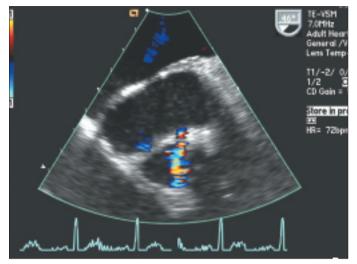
Transesophageal color Doppler images showing bidirectional flow. During systole, blood flows into the pseudoaneurysm (A) and in diastole into the aorta (B).
